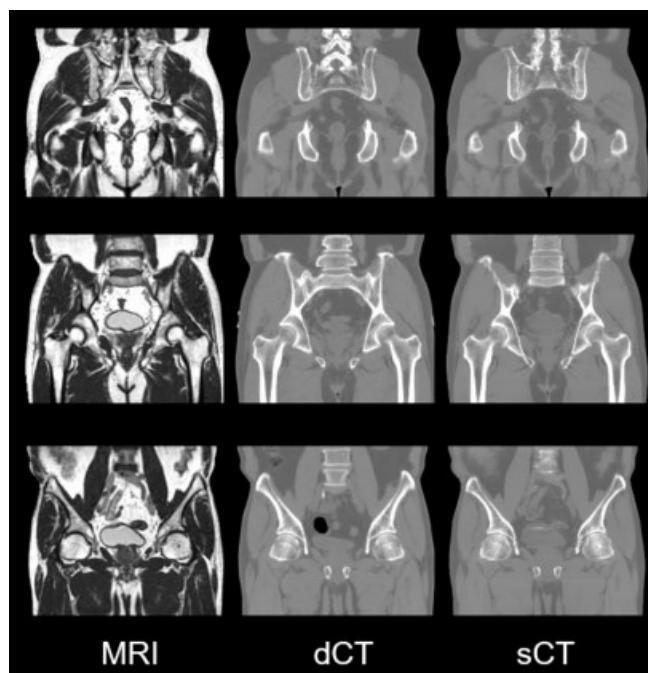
The representative coronal slice views of MRI, dCT and sCT for pelvis
